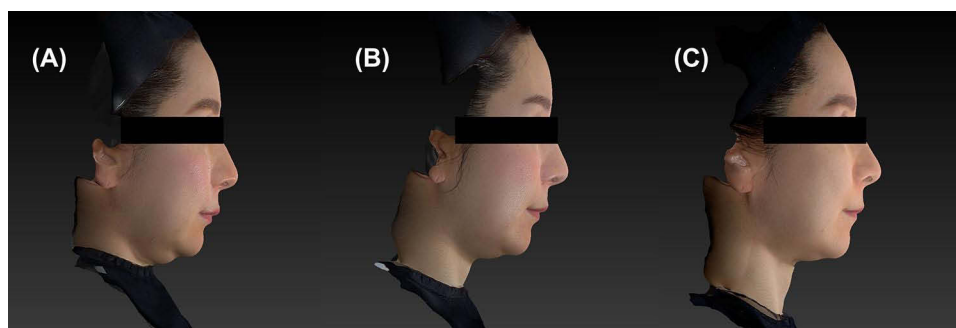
Sequential improvement in chin projection and cervicomenal angle following hyaluronic acid (HA) filler injection followed by high-intensity focused ultrasound (HIFU) treatment in Case 2. (A) Pretreatment image showing moderate submental fullness and insufficient anterior chin projection. (B) Six weeks after treatment, demonstrating improved chin projection and jawline definition with reduction of submental convexity. (C) Twenty-four weeks after treatment, showing sustained improvement in chin projection and lower facial contour without evidence of recurrent submental fullness.
